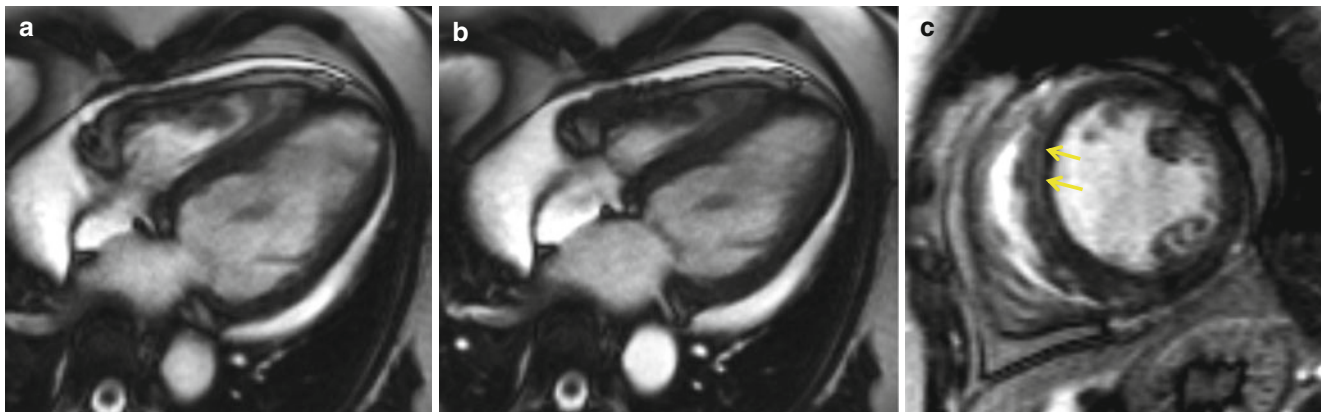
MRI of a female patient with long-term treatment of doxorubicin for malignancy (<http://extras.springer.com/2015/978-3-642-36396-2>). (a) Four-chamber cine MRI shows a dilated left ventricle and impaired systolic contraction of the left ventricle (b systolic phase). Calculated left
